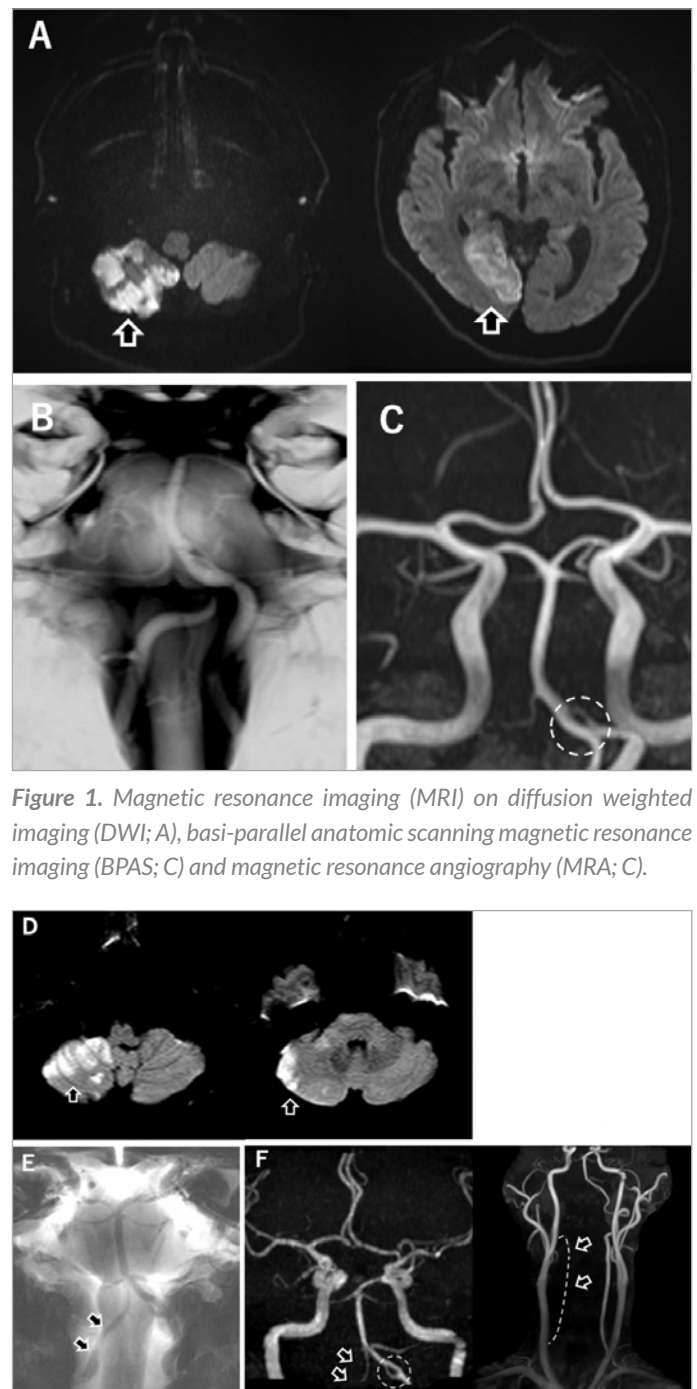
Magnetic resonance imaging (MRI) on diffusion weighted imaging (DWI; A), basi-parallel anatomic scanning magnetic resonance imaging (BPAS; C) and magnetic resonance angiography (MRA; C).
